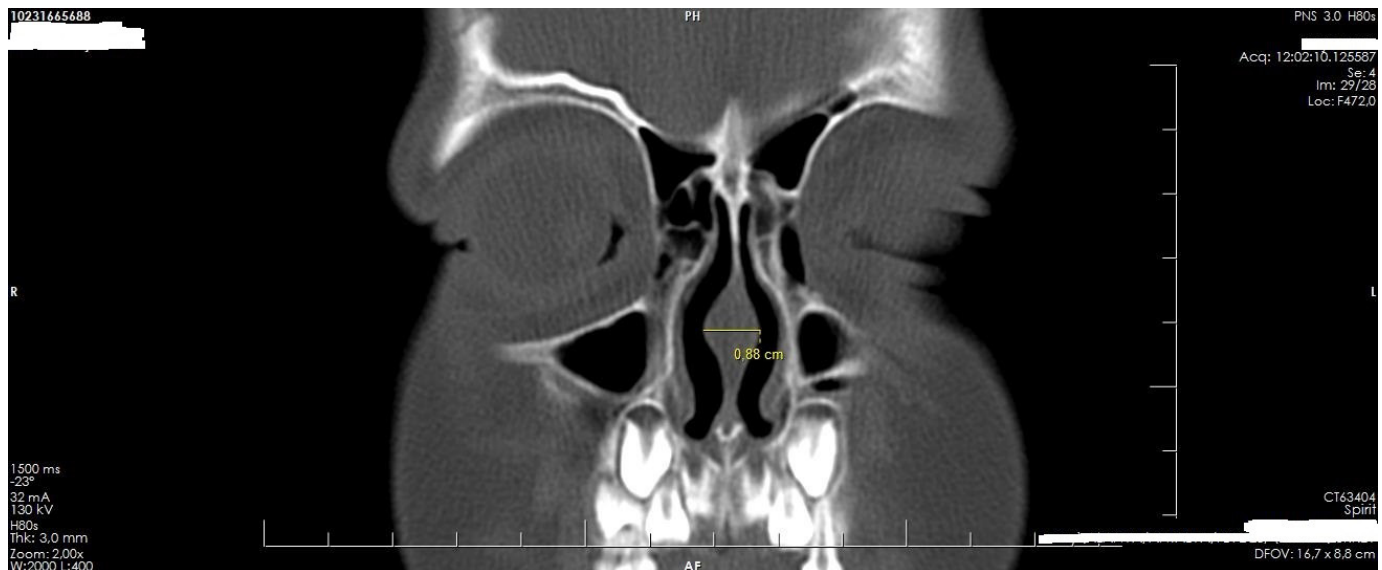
Measuring the widest horizontal part of the nasal septal body on paranasal computed tomography coronal sections
